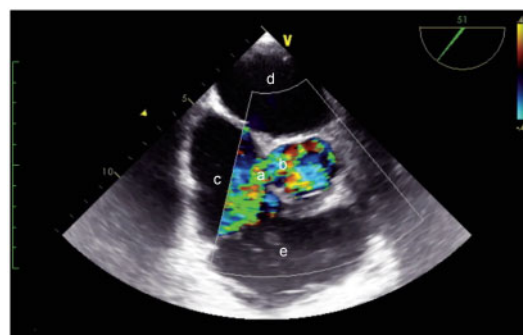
Transoesophageal echocardiography showing a 6 mm colour jet (a) originating from the non-coronary cusp of the aortic root (b) towards the right atrium (c). Left atrium (d). Right ventricular outflow tract (e).
